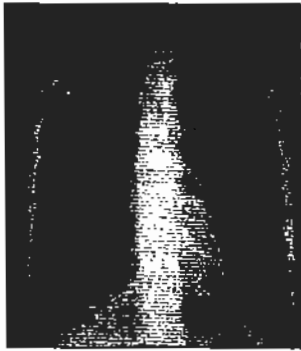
Chest X-ray showed fibro infiltrates
